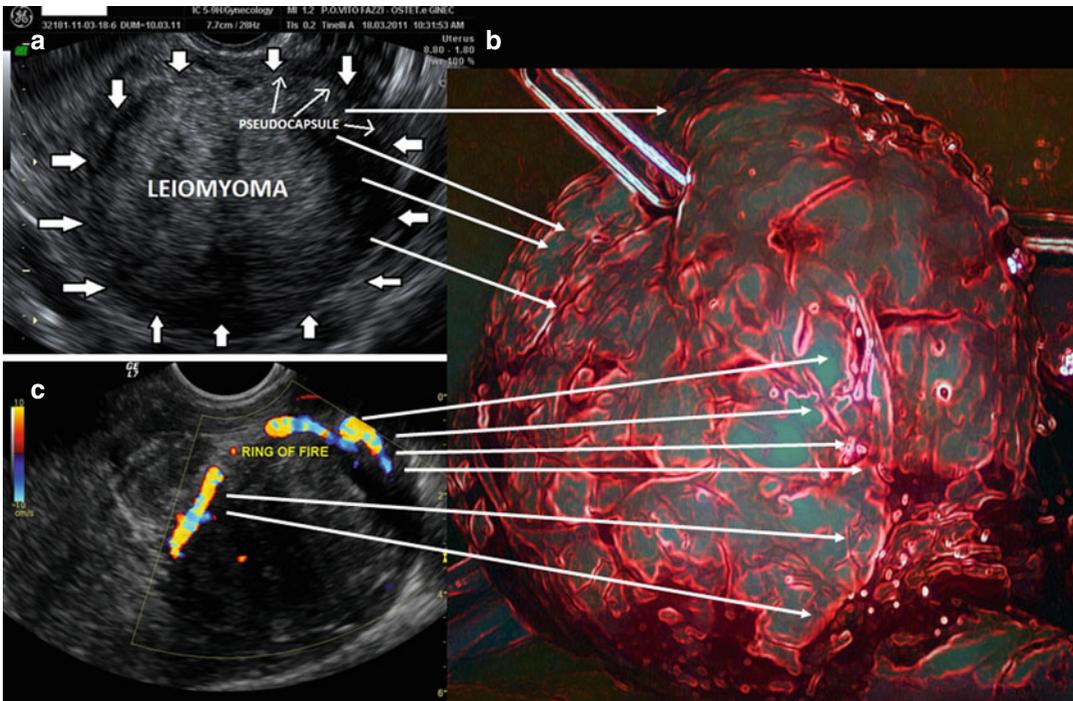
Ultrasonographic scan of myomas and its pseudocapsule; (a) in the top on the left, the pseudocapsule highlighted by arrows; (b) in the lower left, the echo
